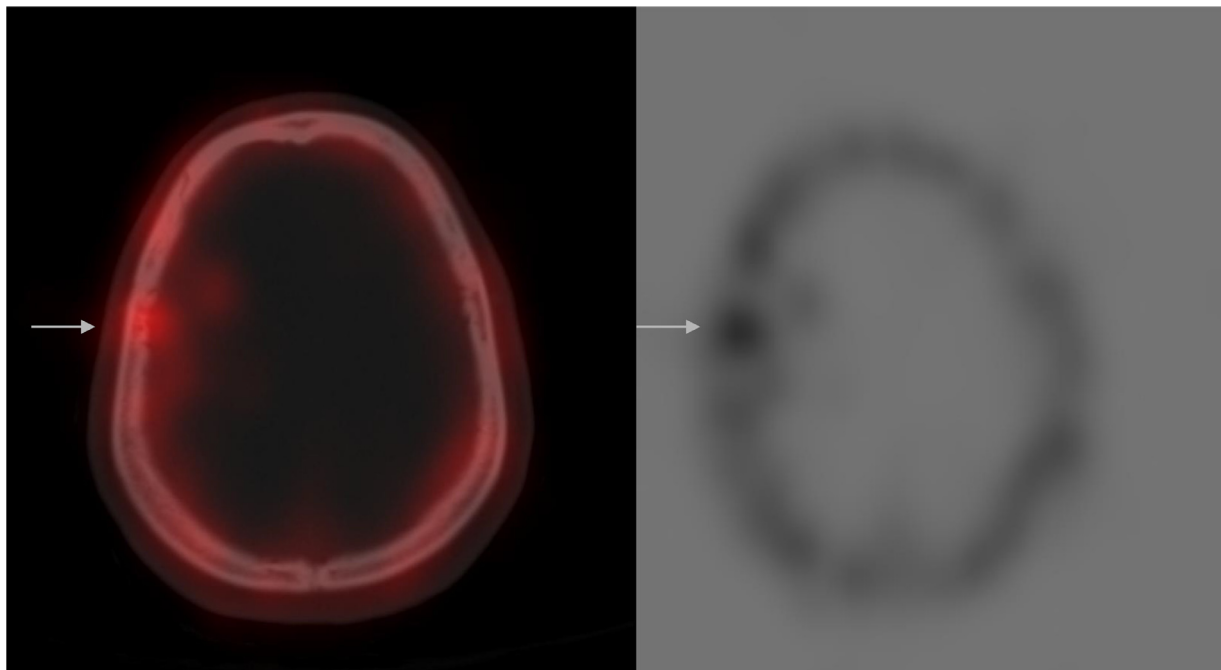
SPECT scan showing a focal uptake at the right fronto-parietal bone (white arrow).
